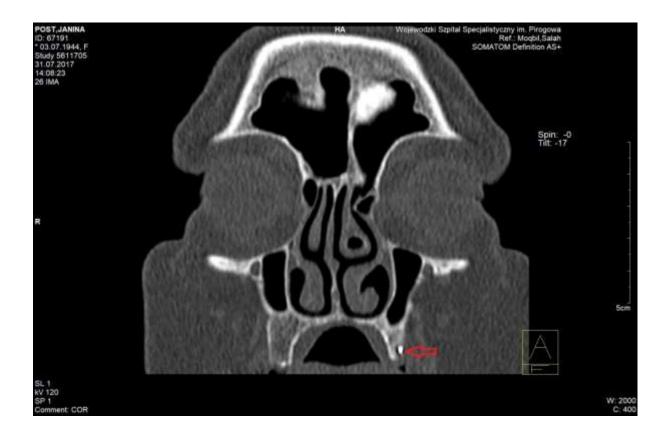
CT of the sinuses with visible endodontic material, in the direct proximity of the sinus' fundus.
